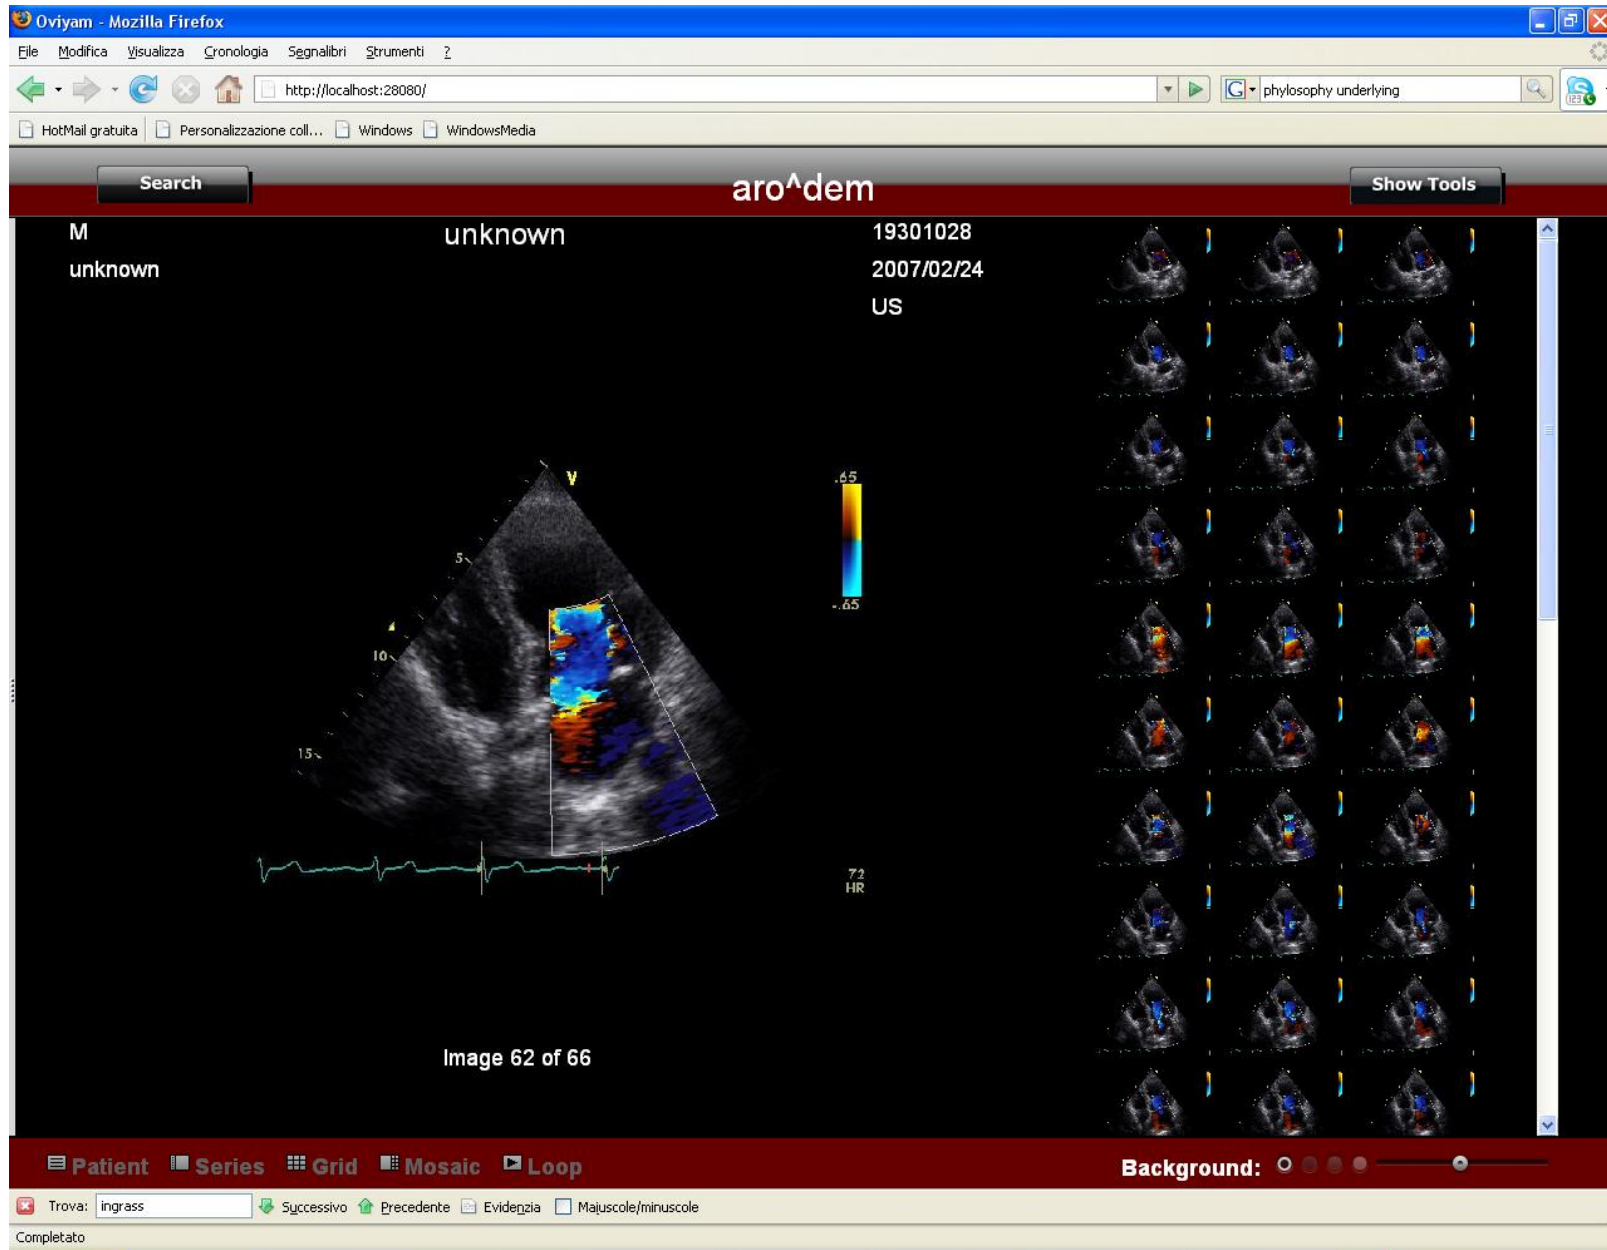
Visualization of a Doppler image sequence. Thumbnails on the right column allow to quickly select images.
